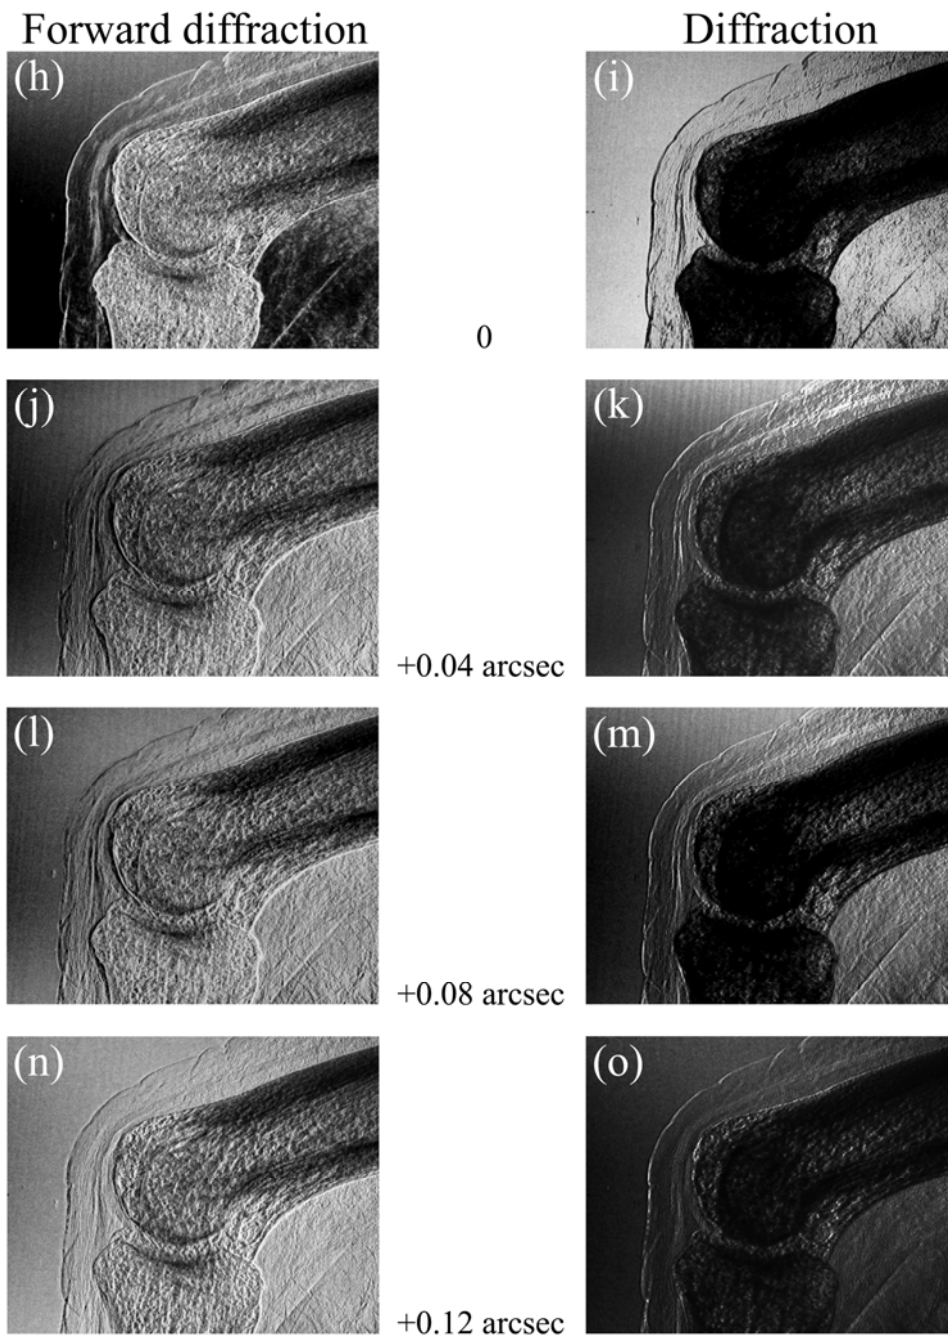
X-ray images of PIP joint with a small lesion with an intensifying screen.
